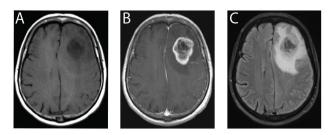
MRI is the primary diagnostic tool for GBM.
